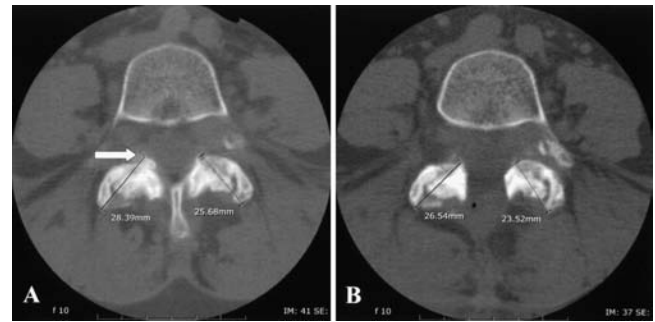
Preoperative (A) and postoperative (B) axial CT scans demonstrating the facet joint at the level of spondylolisthesis. The first axial image (3-mm cuts) below the pedicle was selected in each case and the superior facet (from the vertebral body below the spondylolisthesis) was measured. The arrow indicates an osteophyte removed during decompression. The extent of facet removal was expressed as a percentage based on the following formula: postoperative facet length/preoperative facet length.
